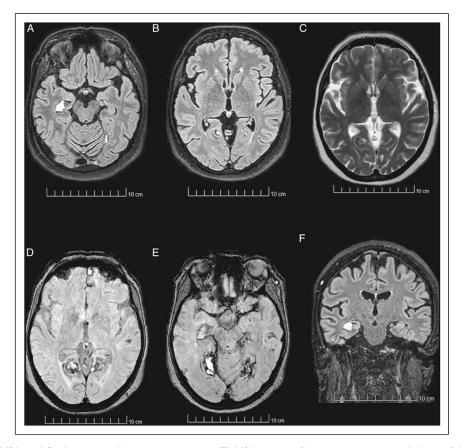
1.5 Tesla MRI axial fluid-attenuated inversion recovery (FLAIR) images of the patient one-month-later of the onset of symptoms demonstrate residual hyperintensity lesion on the right temporal lobe (A) and resolution of the other lesions (B). On the axial T2-weighted image, no lesions are detectable. (C). Axial susceptibility-weighted imaging (SWI) shows slightly hypointense lesions in the left temporooccipital region and hyperintense lesions in the right temporooccipital region, and both occipital lobes (D, E). Coronal FLAIR image demonstrates residual right hippocampi involvement (F).
